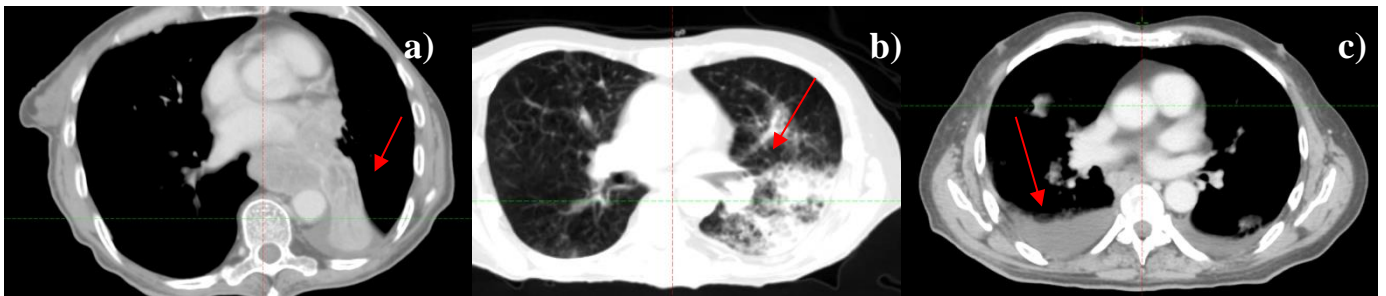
a) Atelectasis (red arrow) in thorax in a CT image, b) Pneumonitis (red arrow) in the lung lobe and c) Pleural fluid in both lung lobe.
